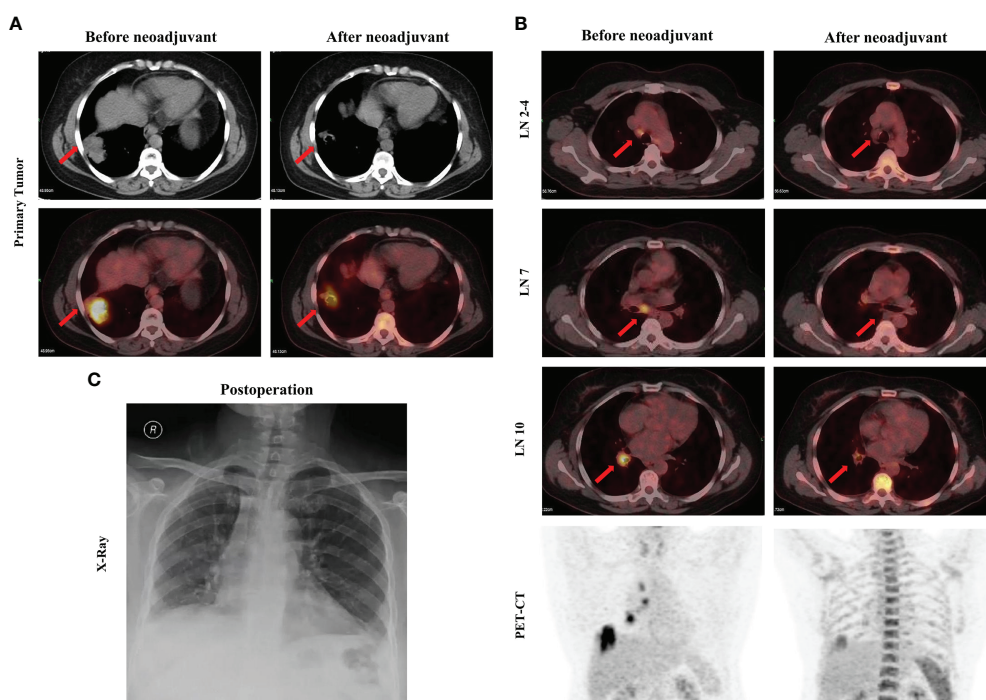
Images before and after neoadjuvant pralsetinib treatment. (A) Enhanced CT and PET-CT of the primary tumor. (B) PET-CT of the mediastinal lymph nodes and the chest. (C) X-ray after surgery.
